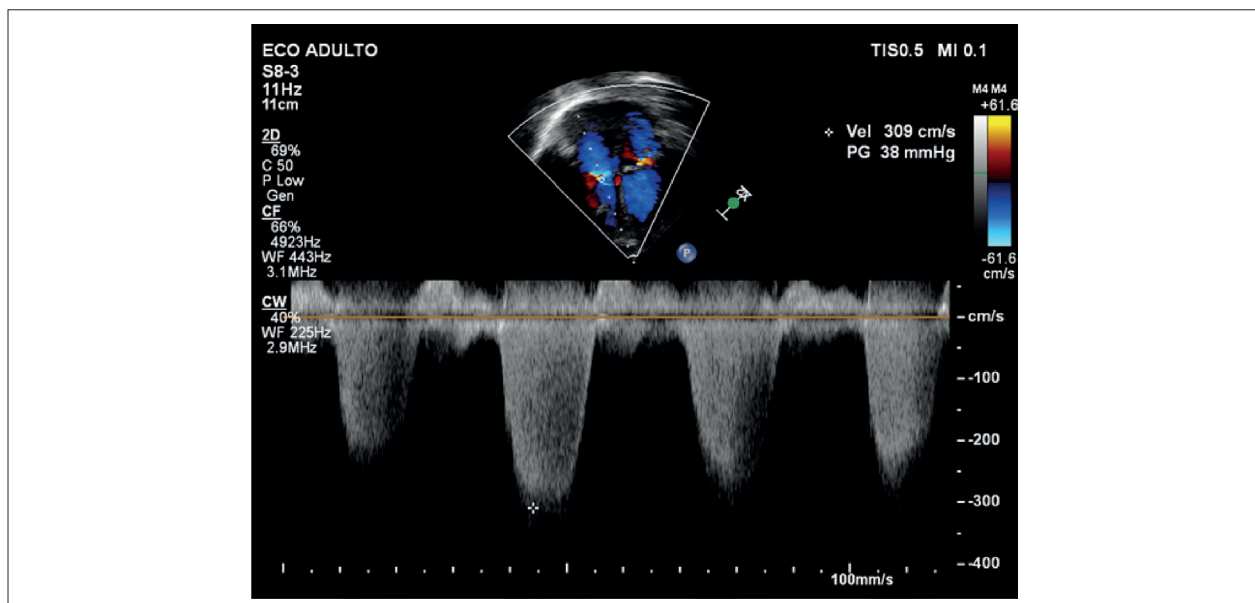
Tricuspid valve Doppler showing regurgitation jet and estimation of pulmonary systolic pressure in patients with pulmonary hypertension.
